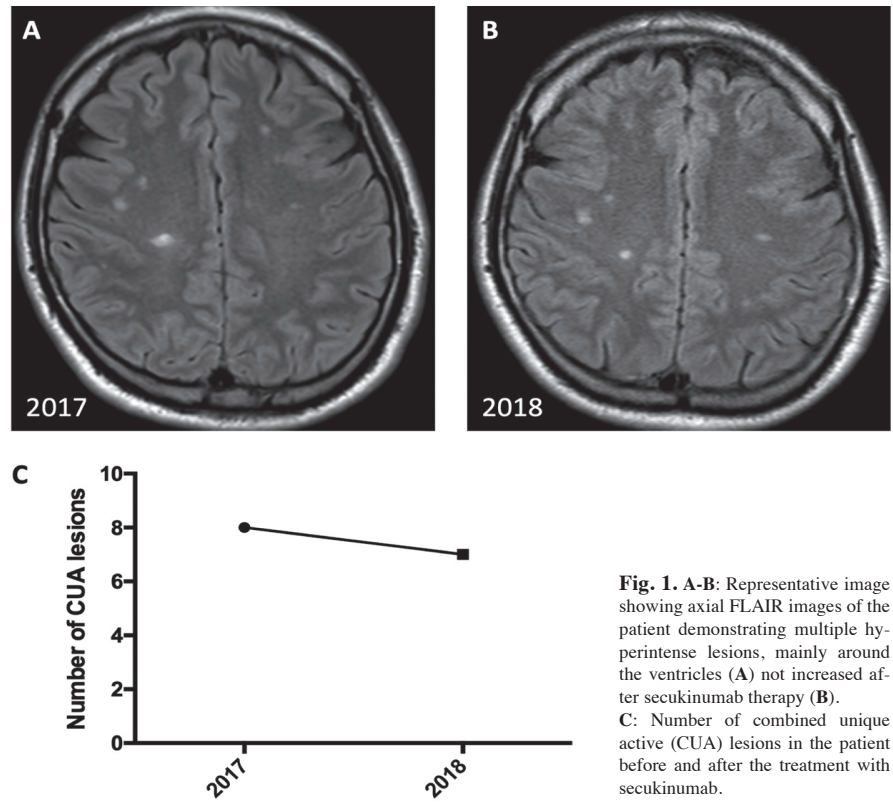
A-B: Representative image showing axial FLAIR images of the patient demonstrating multiple hyperintense lesions, mainly around the ventricles (A) not increased after secukinumab therapy (B). C: Number of combined unique active (CUA) lesions in the patient before and after the treatment with secukinumab.
